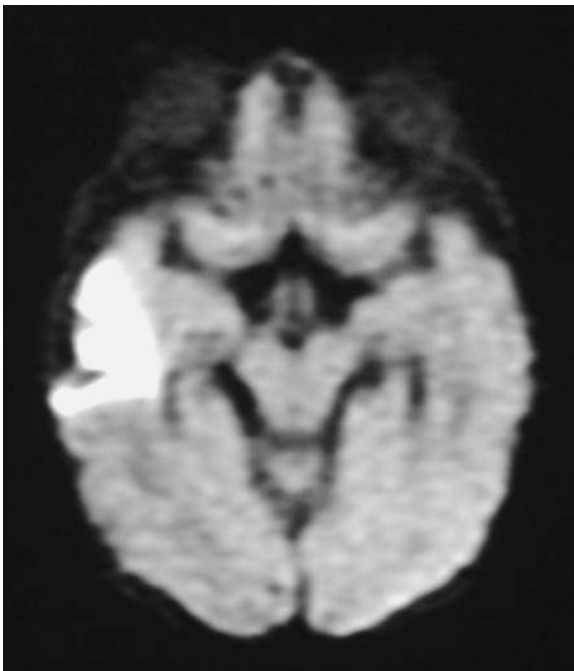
One-month-old baby with encephalopathy. Axial diffusion weighted MR images show high signal in the right temporal region. This region was normal on T2-weighted sequences. This baby has a stroke, and diffusion images are the most sensitive sequence
